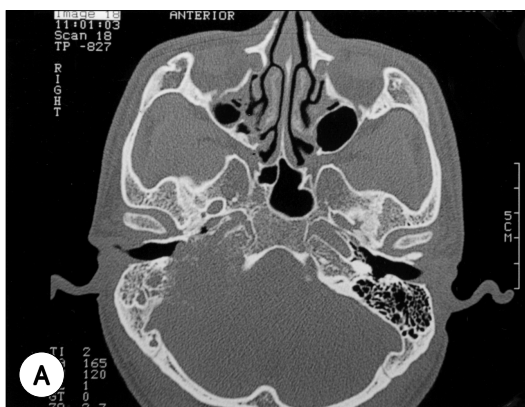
Preoperative radiologic findings. A : Temporal bone CT scan shows a huge mass destructing IAC, and petrous bone. B : MR image shows a highly vascular tumor invading temporal bone and CP angle.
